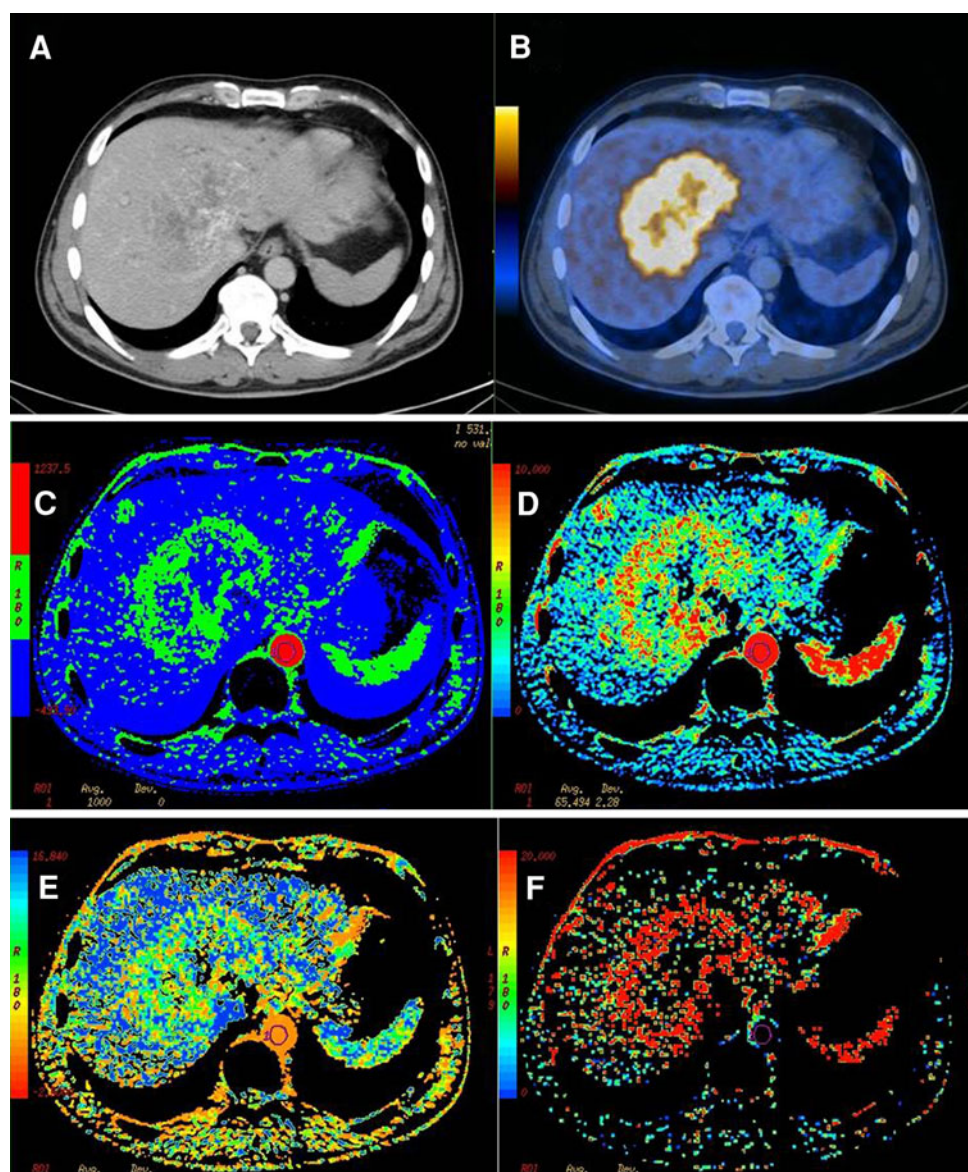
Fifty y/o male patient with history of a colorectal cancer and hepatic metastases 1 week after chemotherapy. The ce-CT (A) shows partly necrotic areas in this large liver metastases, the corresponding PET/CT (B) shows high FDG-avidity in the peripheral vital and centrally necrotic metastases. Corresponding parametric perfusion images shows the metastases of the patient as blood flow (C) and blood volume image (D). E and F showing the corresponding images for mean transit time and permeability surface. The metastases of this patient showed a high FDG-avidity (SUVmax: 11.5) and high perfusion values (BF: 47.4 mL/100 g tissue/min, BV: 6.2 mL/100 g tissue, MTT: 11.4 s, PS: 20.8 mL/100 g tissue/min). SUVmax/mean, PETvol/TLG: PET-data of the liver lesions.
